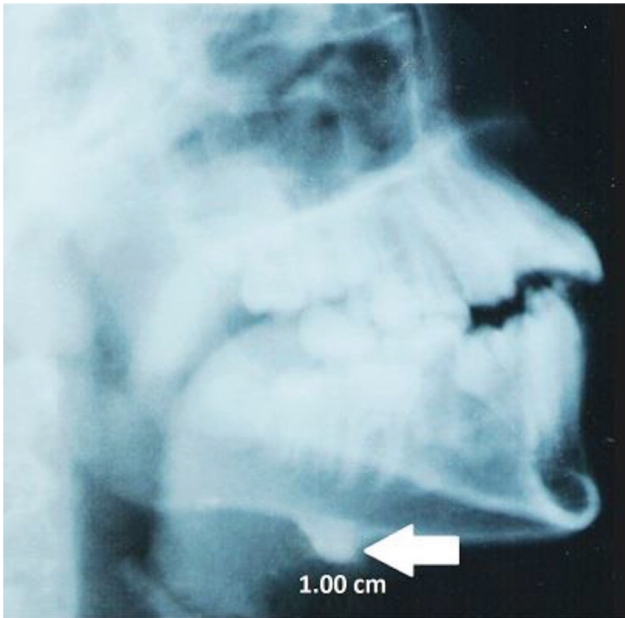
X-ray lateral mandible showing well-defined, rounded, radiopaque bony lesion at the inferior border of the right mandible measuring about 1 cm in diameter.
